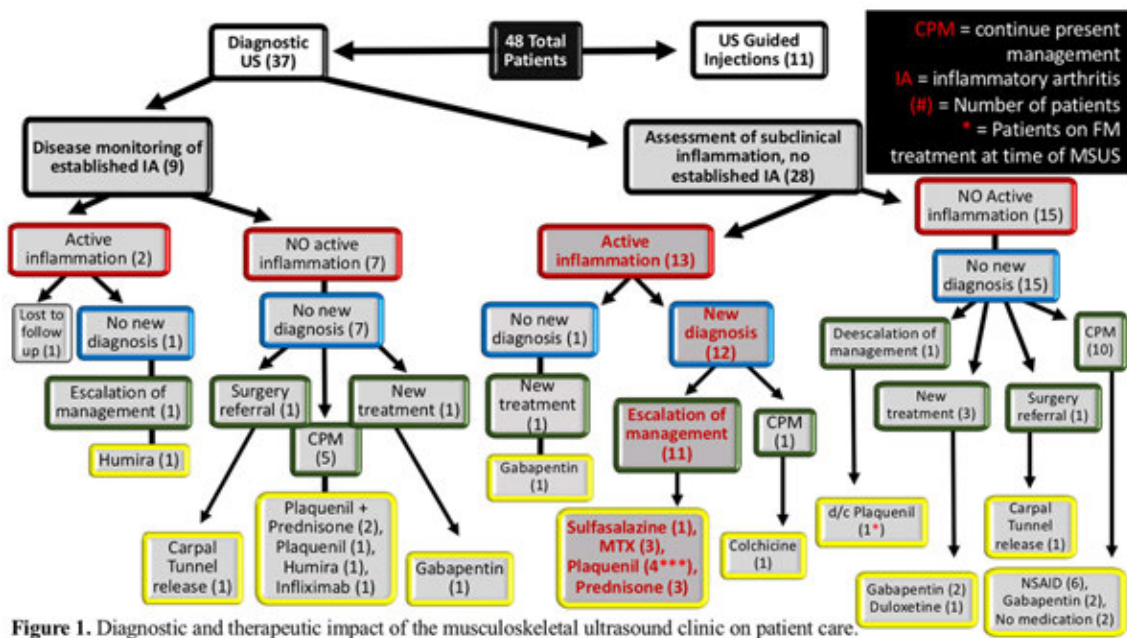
Diagnostic and therapeutic impact of the musculoskeletal ultrasound clinic on patient care.
